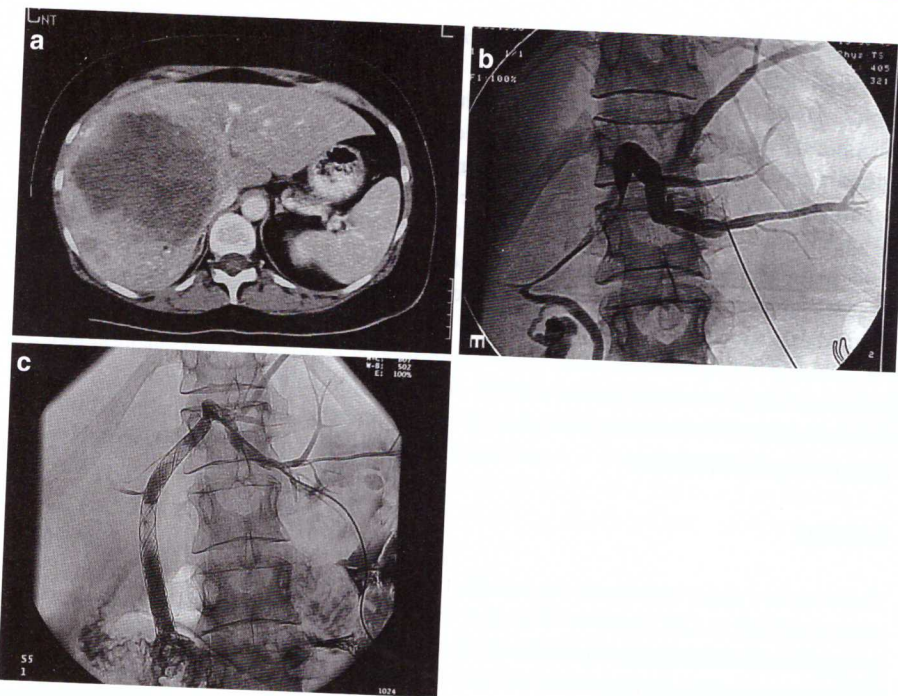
(a) Computed tomography (CT) scan with a large liver tumor in a jaundiced patient. (b) Only a peripheral left liver puncture can be performed with safety. (c) Metallic stent in situ
